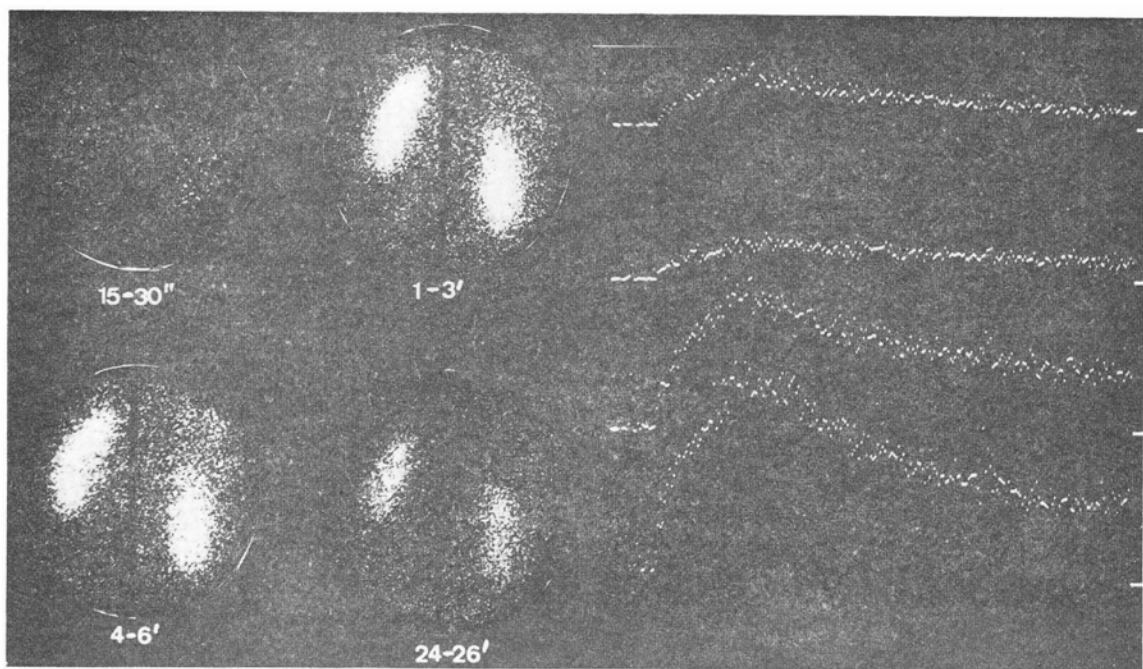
Serial scintigraphy and integral curves of both kidneys in nephrosclerosis after i. v. ^{131}I -o-Iodhippuric acid ($500\ \mu\text{Ci}$): delayed inflow, distinct concentration, nearly no transport within the organs and delayed evacuation. Contracted right kidney.
